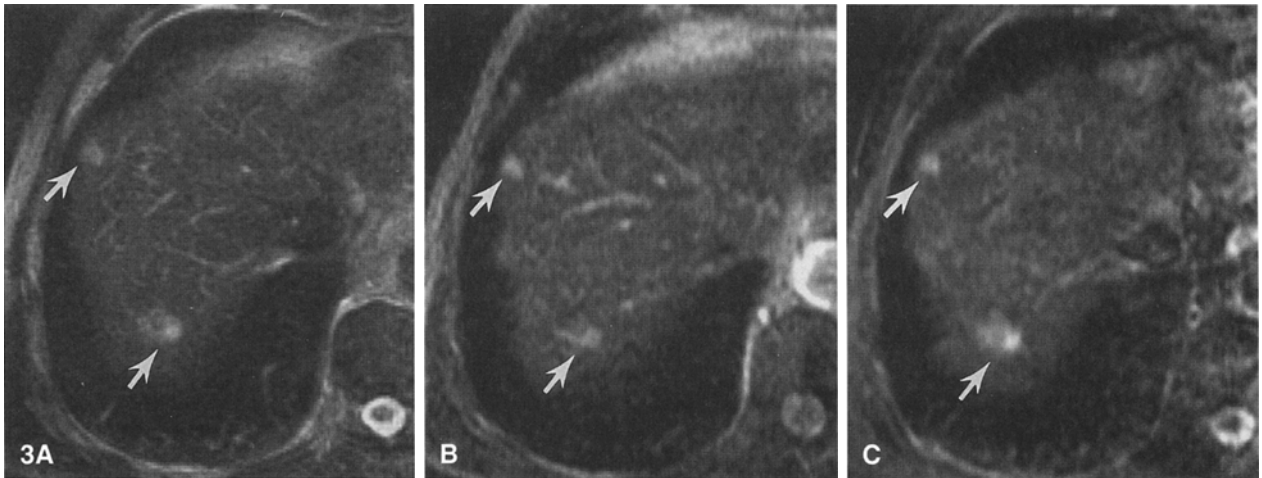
MR images of the dome of the liver in a patient with metastasis (arrows) from breast cancer. A R. trig. FSE. B CSE. C STIR. Note severe image degradation due to motion artifact in the STIR image. Time of image acquisition for the R. trig. FSE sequence was 6 min 20 s versus 10.7 min for the CSE sequence and 15 min for the STIR sequence.
